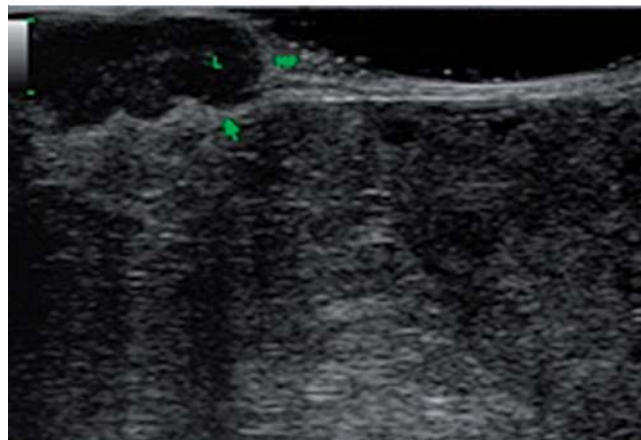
Transrectal ultrasound (TRUS, linear probe): hypoechoic lesion infiltrating the muscularis propria of the rectosigmoid.
